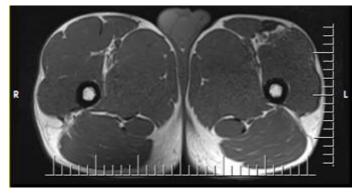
Case 1: RF grade III injury on the left side of the player, who returned to sports with conservative treatment, MR image after recovery
